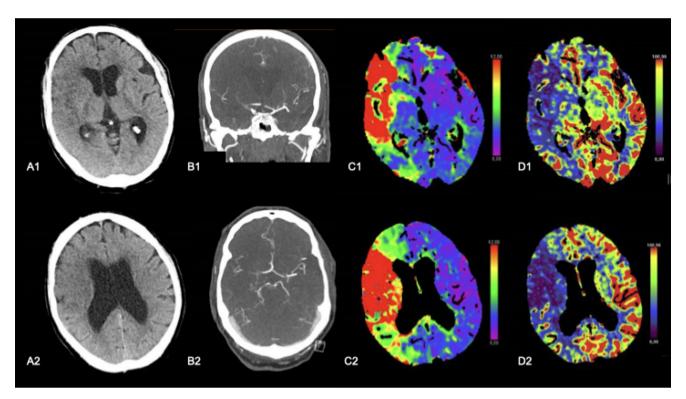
Computed tomography (CT) of the head of a 64-year-old woman with acute ischemic stroke. (A) CT shows slightly enlarged ventricles, and a subtle hypodensity of the gray and white matter: caudate nucleus, internal capsule, insula, and a large part of the superficial distribution of the right middle cerebral artery. ASPECTS 4. (B) CTA shows occlusion of the top of the internal carotid artery, extending into the middle cerebral artery and the origin of the anterior cerebral artery. (C) Perfusion CT shows an area with prolonged T-max and a smaller area in dark blue with a low relative flow. The area with T-max > 6 s has been estimated at 177 mL, and the area with relative CBF of less than 30% is 81 mL, leaving 96 mL for the penumbra.
